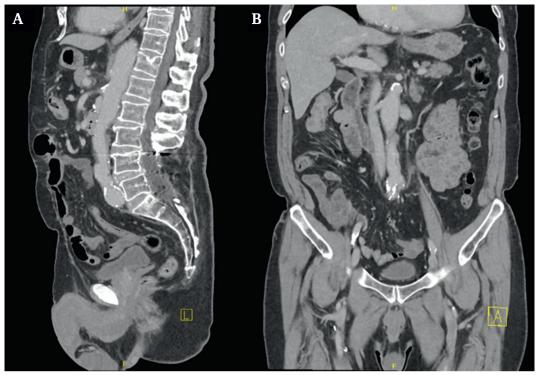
(A) Computed tomography (CT) abdomen and pelvis showing appearance of the aorta post-repair with reversed right superficial femoral vein. The aorta is patent, although with a slightly thickened wall which is stable compared with previous post-operative imaging. (B) Coronal view of the same imaging.
